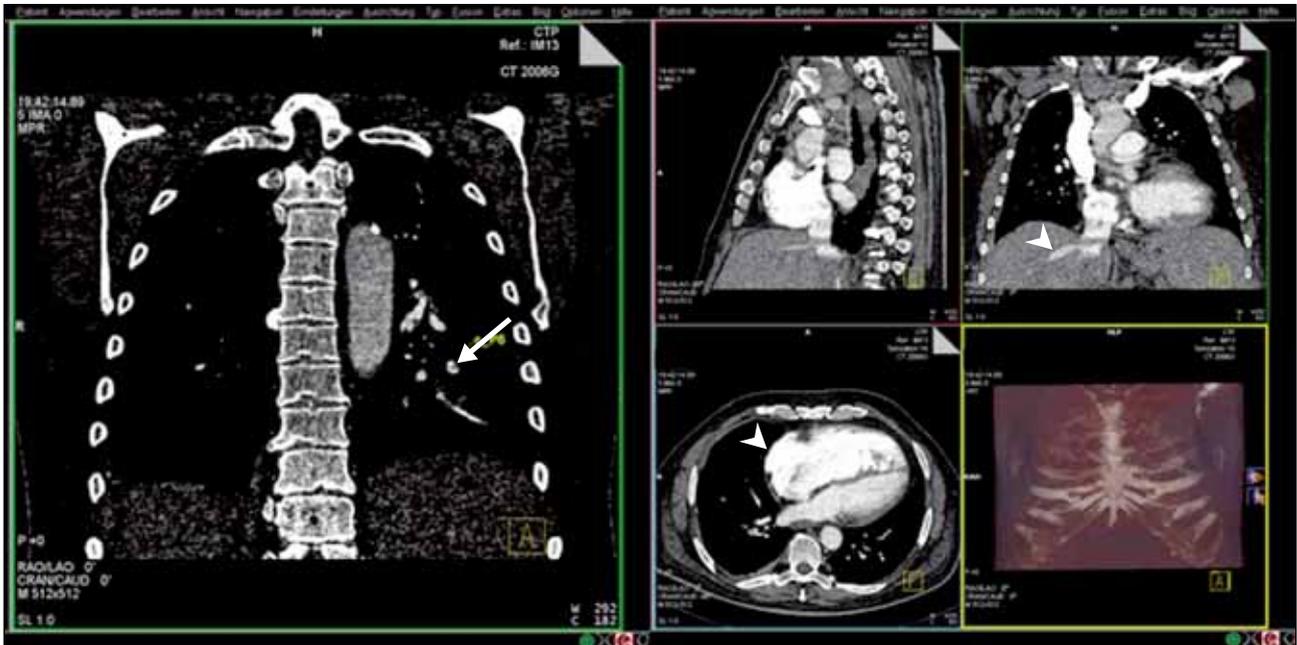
Multidetector computed tomography with computer-assisted diagnosis showing a segmental pulmonary embolus of the left inferior lobe that was missed in the initial read (arrow). There is enlargement of the right atrium and ventricle and contrast material congestion in the hepatic veins secondary to right heart failure (arrowheads).
